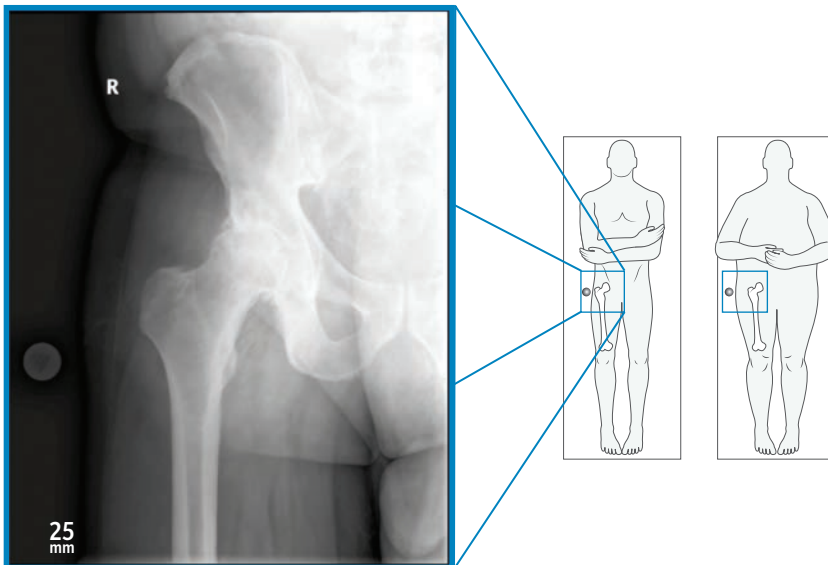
Preoperative Unilateral AP X-ray Top View
